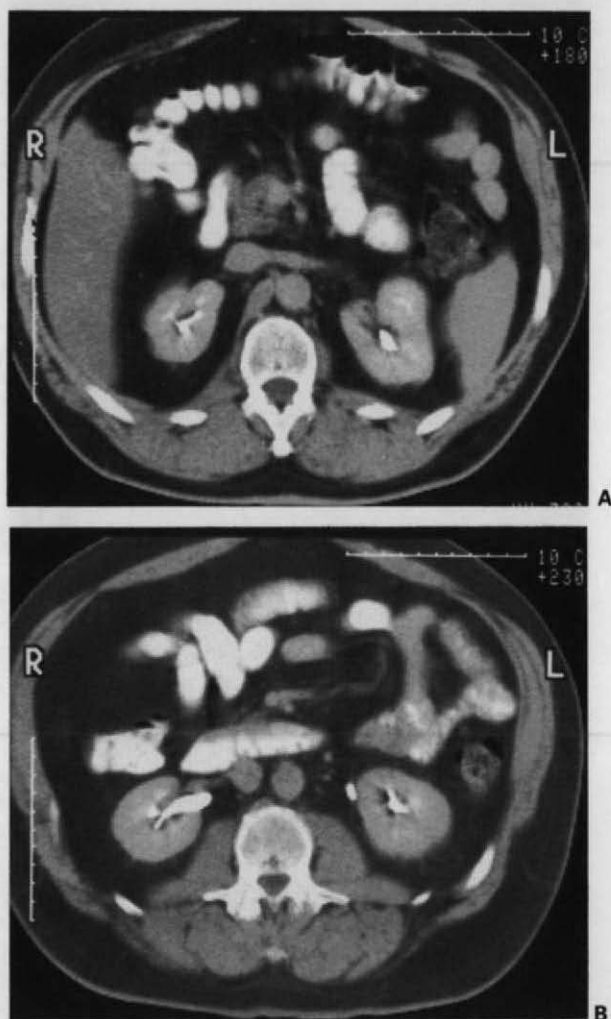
CT scans of the upper abdomen (viewed by convention from below). In A, the left renal vein crosses in front of the aorta to enter the inferior vena cava. In B, the pelvis of the right kidney is indicated by the white opacity (representing oral contrast medium which has been absorbed and excreted by the kidney), while on the left side the ureter, similarly outlined, lies immediately medial to the lower pole of the kidney.
